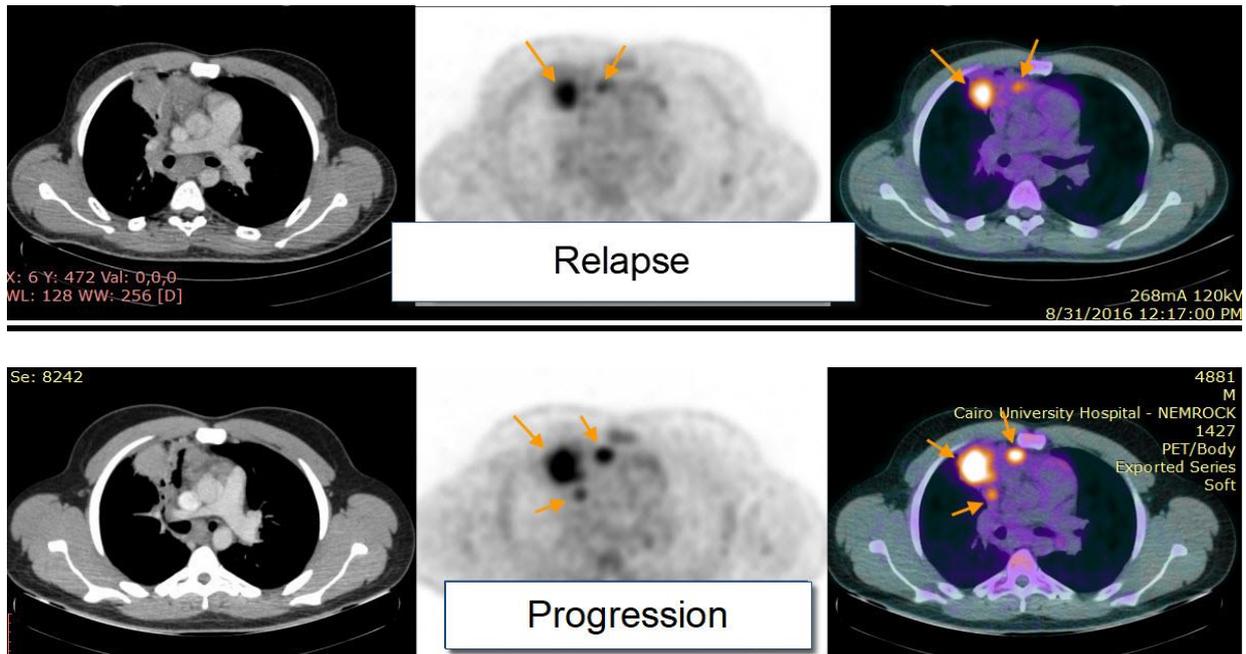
(A): 23 year old male with mantle cell lymphoma with stage III with relapse involving anterior mediastinum and pulmonary lesions together with inactive sub-carinal LN as seen in PET/CT scans.
